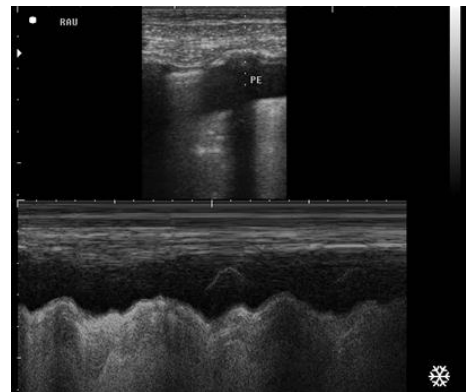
(b) Twelve 12 months' old female baby fever, cough, difficulty in breathing and lethargy. Ultrasonographic showed the massive right pleural effusion which was not documented clinically despite that they had no diagnosis of pneumonia US also concluded not to be pneumonia
